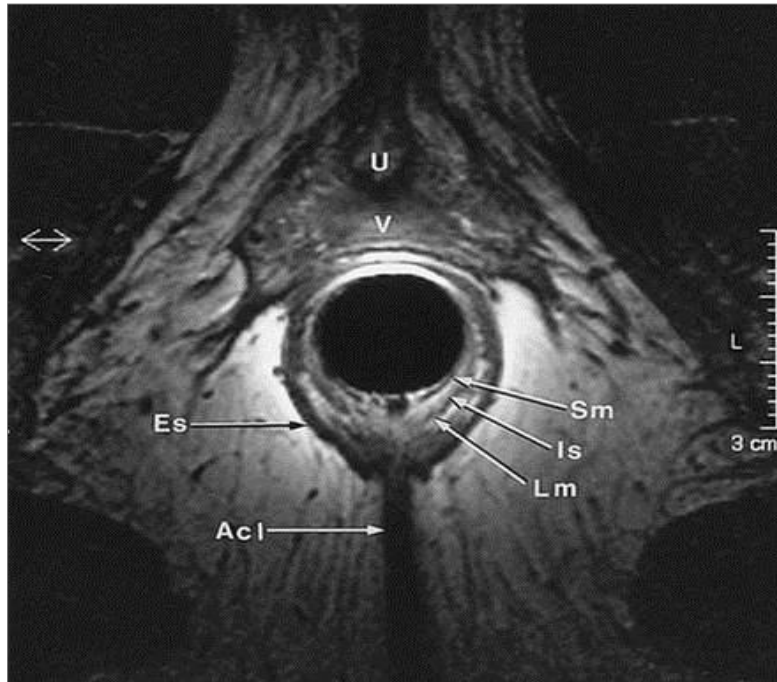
Static MRI. Axial image of the anal canal. U: urethra; V: vagina; SM: submucosa; IS: internal sphincter; LM: longitudinal muscle; ES: external sphincter; ACL: anococcygeal ligament
